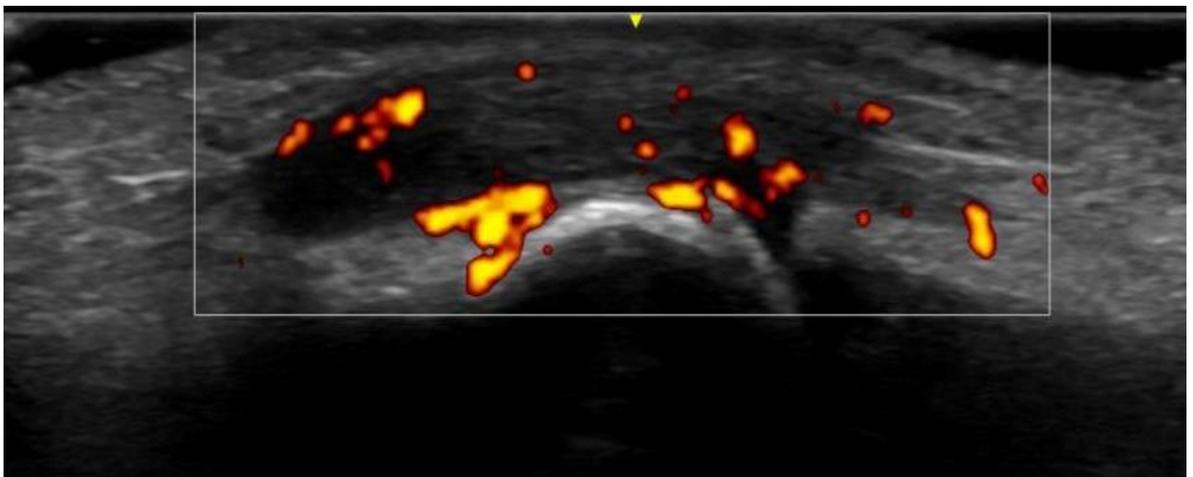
Longitudinal dorsal scan of the third proximal interphalangeal joint of the left hand showing synovial hypertrophy grade three with power Doppler signal graded two (Author's own, 2025).
